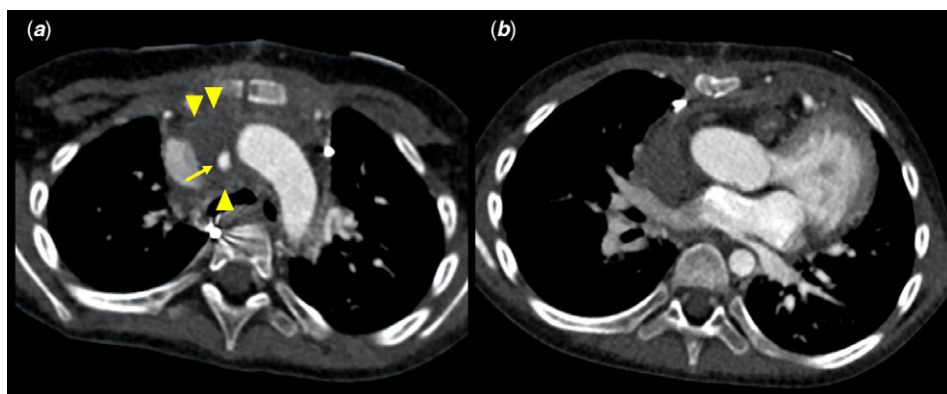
(a) Post-operative computed tomography showing that the Blalock-Taussig shunt had opened (arrow) and the perigraft seroma persisted (arrow heads). (b) Serous fluid accumulation on the posterior aspect of the left atrium had disappeared.
